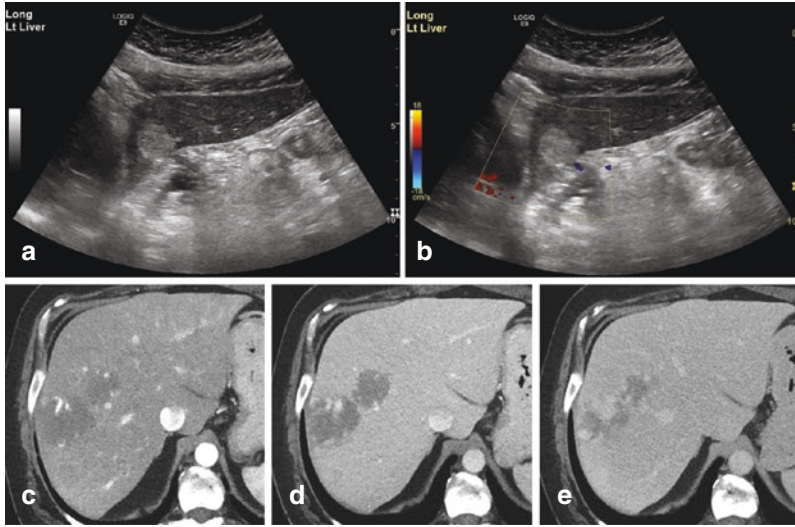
Hemangiomas, classic appearance. Grayscale sonographic images of the left lobe (a) show a homogeneously hyperechoic mass with no increased blood on color Doppler (b). While the sonographic appearance alone is nonspecific, this mass was later imaged with multiphase CT confirming the diagnosis of a cavernous hemangioma. Axial CT images in the arterial (c), portal venous (d), and 3-minute delayed (e) phases show two adjacent hypodense foci with discontinuous nodular enhancement and progressive fill-in over time, classic features of a cavernous hemangioma
